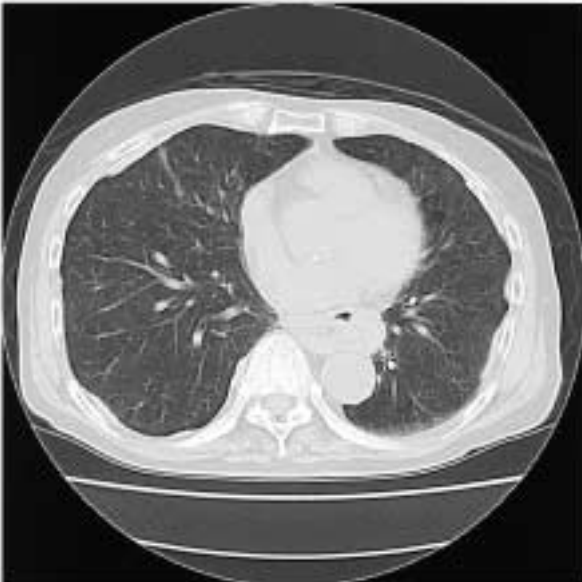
Computed tomography (CT) image showing a diverticulum of the esophagus located between the heart and the aorta.
